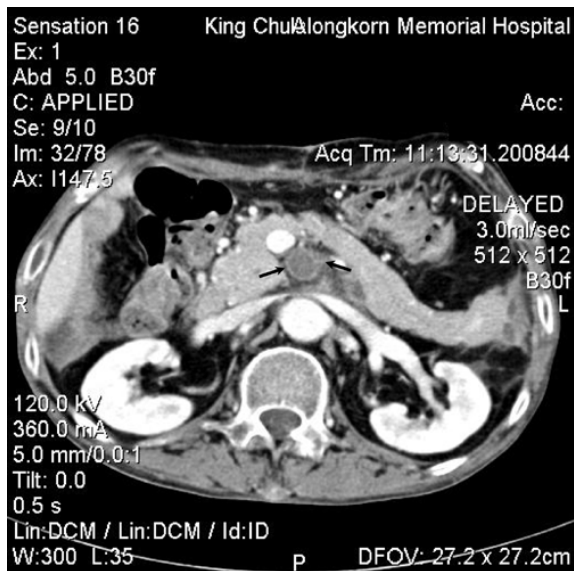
Computed tomography of the abdomen 3 weeks after ligation of the SMA proximal and distal to the SMAA. There is no visualization of the contrast material in the thrombosed SMAA
